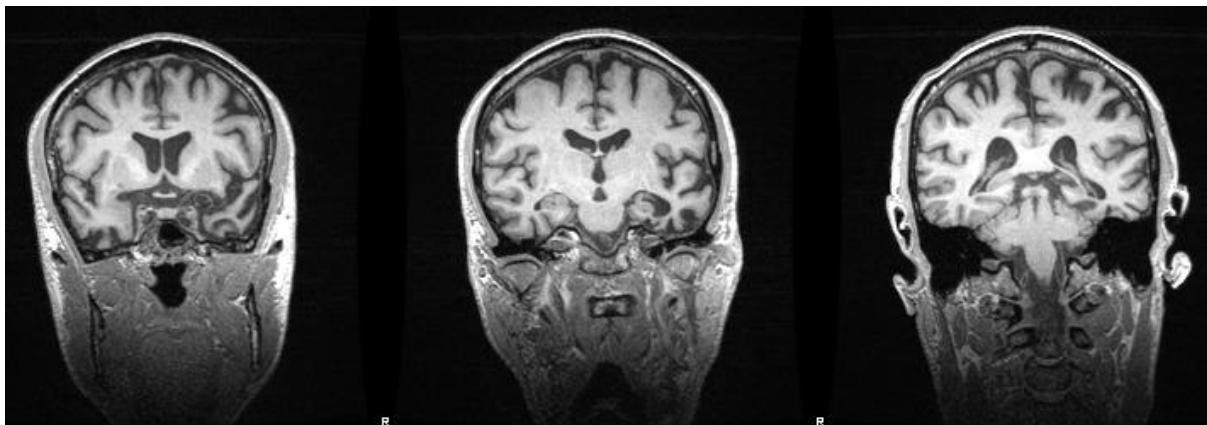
Coronal view of an MRI of a patient with svPPA. The images demonstrate characteristic temporopolar grey matter atrophy consistent with a diagnosis of left-lateralised svPPA.
